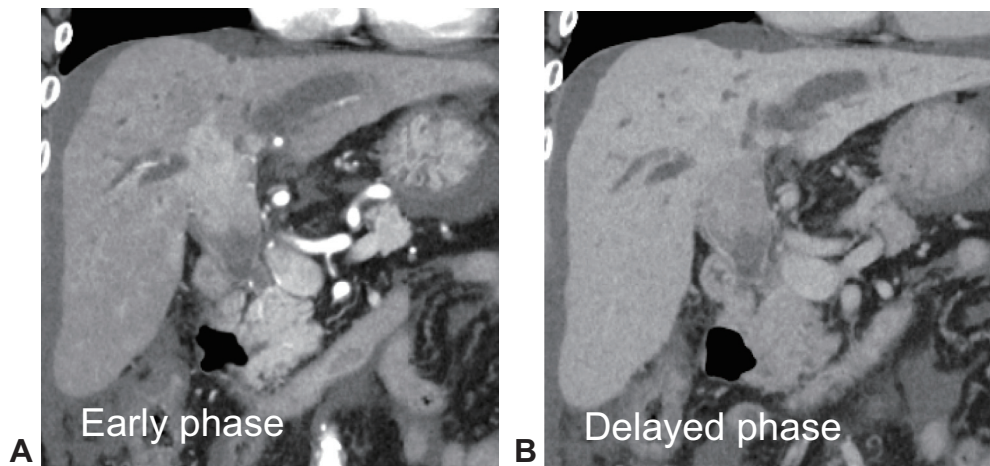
Dynamic CT 10 months after diagnosis. Contrast-enhanced CT revealed a mass that had grown to dilate the hilar bile ducts. Tumor invasion was identified in the liver that was contrasted in early phase (A) and washed out in delayed phase (B).
